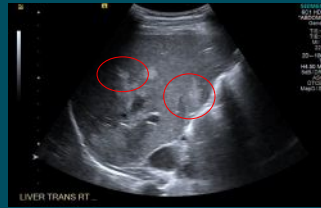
Patient's Liver ultrasound notable for abnormal nonspecific patchy echogenicities in red circles
